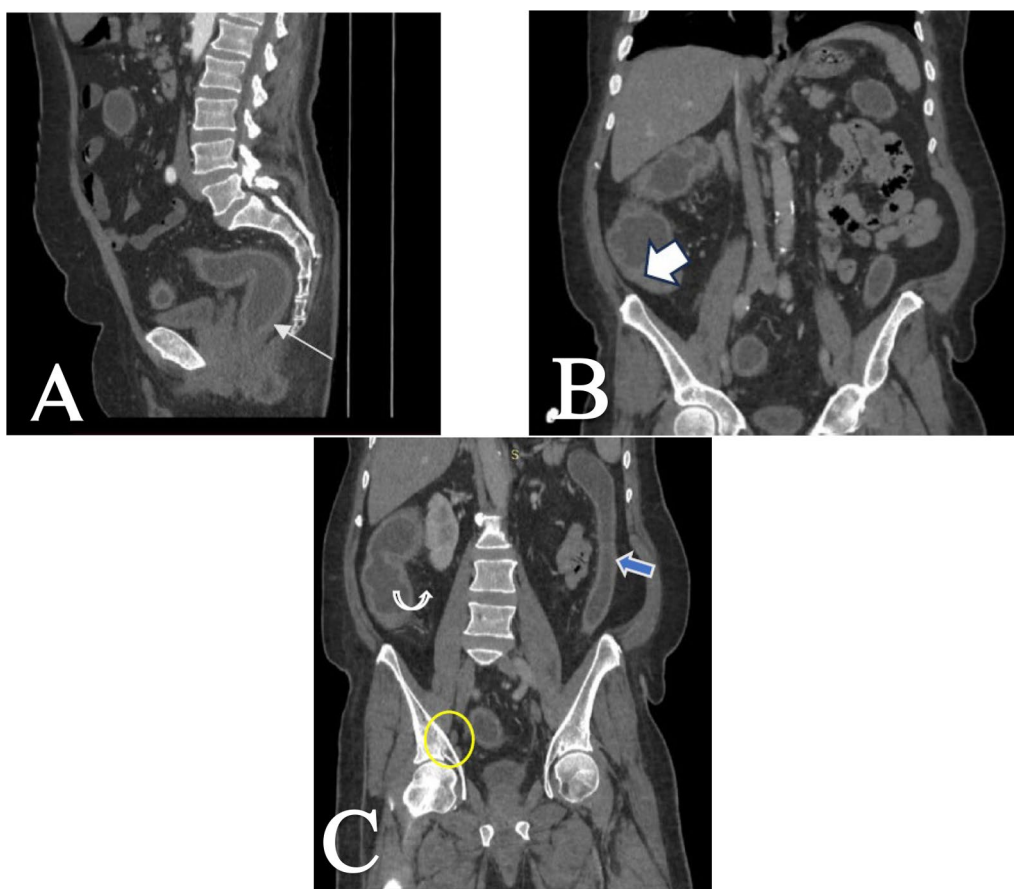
CT enterography with IV contrast (A) sagittal image shows uniform circumferential mural thickening of rectosigmoid with stratification of the rectal wall (arrow). (B) Stratification of the cecum and ascending colon, mucosal hyperenhancement and submucosal edema (arrow) and (C) Coronal image shows loss of haustration (lead pipe rigidity) of the descending colon up to the splenic flexure (arrow), lymph node enlargement (circle), mesenteric hyperemia (curved arrow) CTE score: 14. Modified Mayo score: 9
